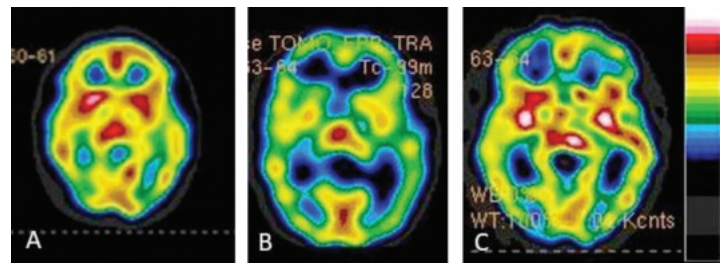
Cross sectional images from brain SPECT scans showing PTSD (A), TBI (B), and the combination of PTSD and TBI (C). Each has a very distinct appearance visually and when the default-mode network is analyzed, these conditions can be differentiated with 94% accuracy.⁶
